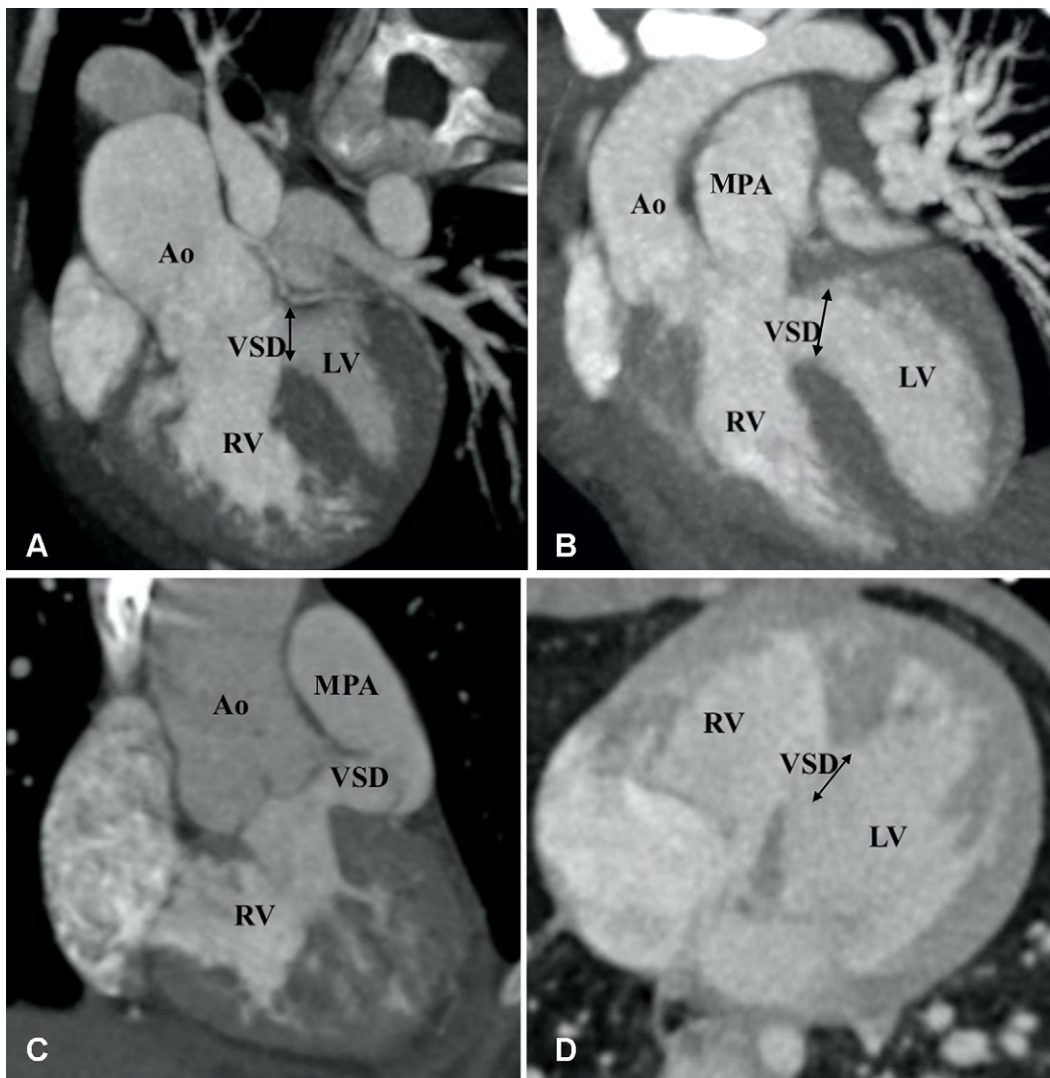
Types of ventricular septal defects (VSDs). (A) Subaortic VSD (double arrow) in a 1-year-old boy with double-outlet right ventricle (DORV). Reformatted coronal maximum intensity projection (MIP) CT image shows greater than 50% aortic overriding. The pulmonary valve and MPA were severely stenotic (not shown). (B) Subpulmonic VSD (double arrow) in a 2-year-old boy with DORV. Reformatted coronal MIP CT image shows the origin of both great vessels from the RV. (C) Doubly committed VSD in a 2-year-old girl with DORV. Reformatted coronal MIP CT image shows the origin of both great vessels from the RV. VSD is closely related to both the semilunar valves (doubly committed). (D) Remote VSD (double arrow) in an infant with DORV. Axial MIP CT image shows remote intramuscular VSD. Ao = aorta, LV = left ventricle, MPA = main pulmonary artery, RV = right ventricle.
